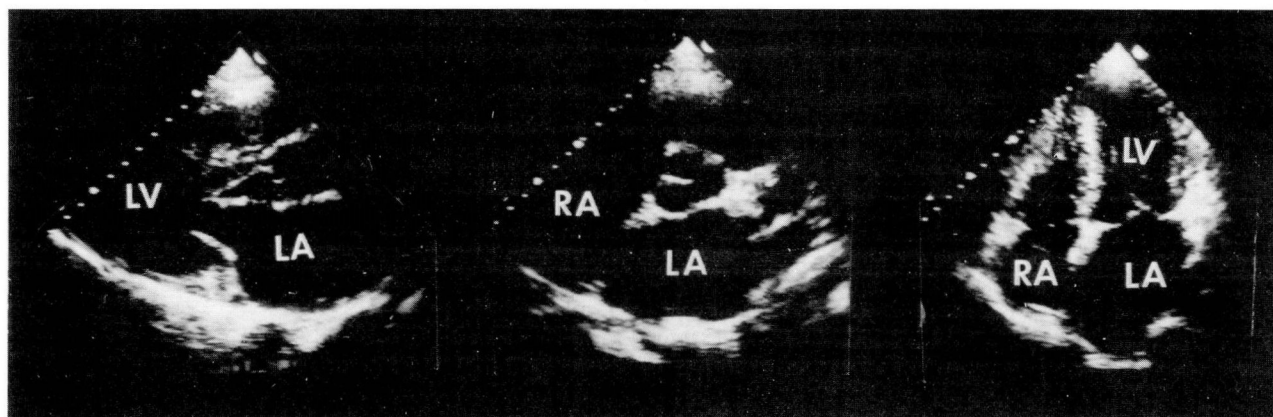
Transthoracic echocardiogram in parasternal long-axis view (left), parasternal short-axis view (middle), and apical four-chamber (right) prior to cardioversion, showing a hypertrophic left ventricle (LV) with a small left ventricular cavity size and a dilated left atrium (LA). A thrombus is present in the left atrium but cannot be seen. (RA, right atrium)
